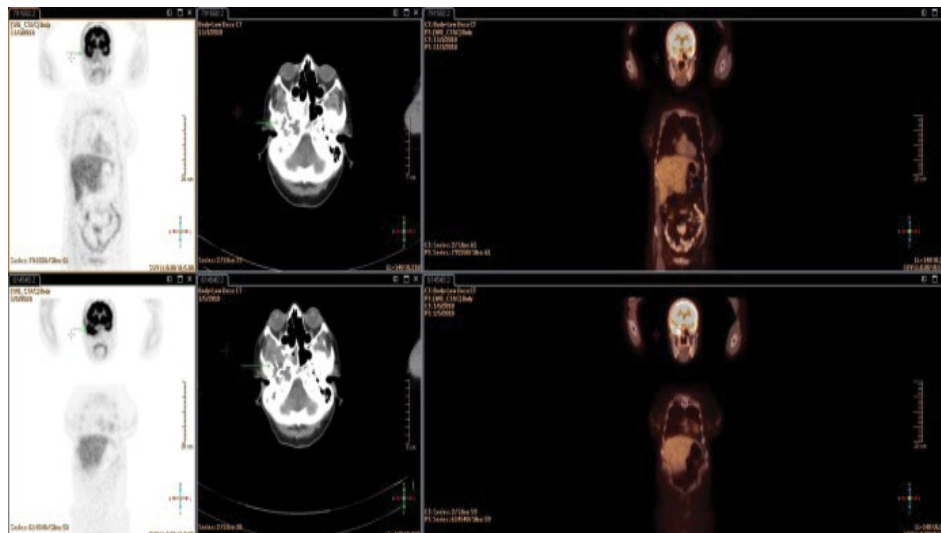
PET/CT of body, revealed metabolic activity of right iliac bone, sella turcica, thyroid nodule of the left lobe of gland and lung.
